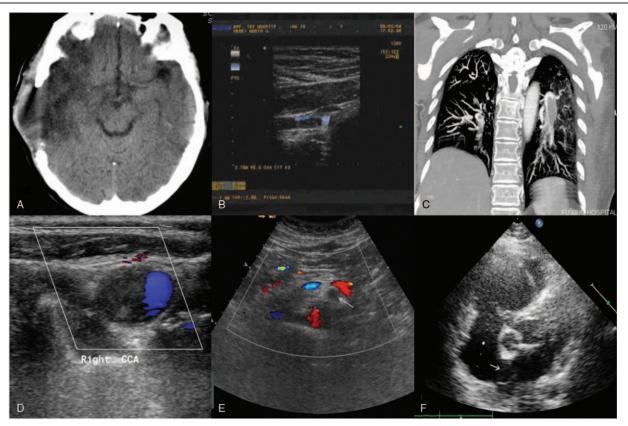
Imaging examinations. Cranial computed tomography (CT) indicated changes after the right temporal decompressive craniectomy (A). Vascular ultrasound revealed solid low echoes at the distal end of the right subclavian artery (B). computed tomography pulmonary arteriography (CTPA) showed wide embolism at the distal end of the bilateral main pulmonary arteries (C). A vascular ultrasound of the neck revealed solid low echoes at the right internal carotid artery (D). The mesenteric arteriovenous ultrasound showed that, the sonolucency of the main trunk and partial branches was poor with no blood flow filling (as indicated by the arrows) (E). Echocardiography indicated the color trans-septal blood flow signals were explored at the oval foramen (as indicated by the arrows) (F).
